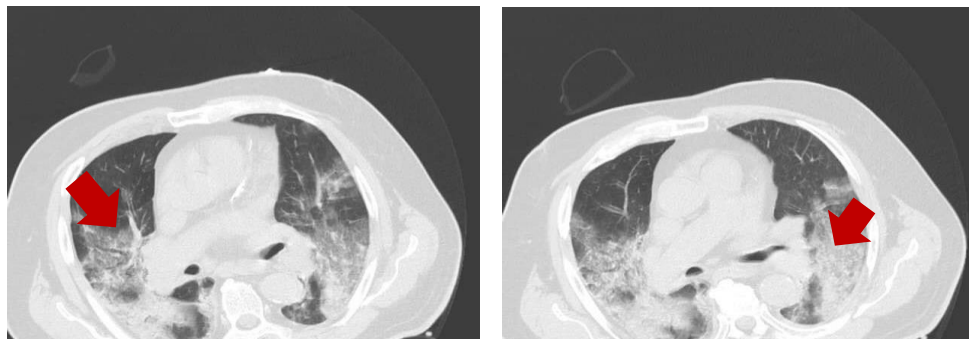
CT chest axial lung window of a COVID-19 patient showing bilateral prominent areas of ground glass opacities, crazy paving pattern and areas of consolidation more prominent at the lung bases.
